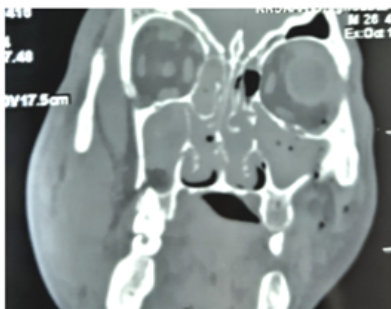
CT NOSE AND PNS CORONAL SECTION SHOWING LE FORT I FRACTURE
